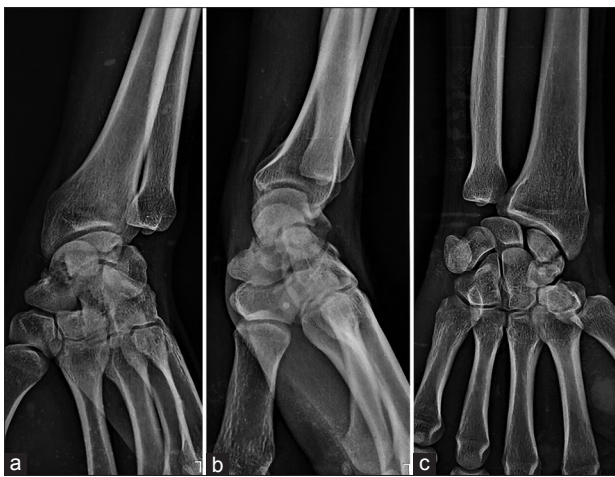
The radiograph showing fracture of scaphoid in oblique (a) and two orthogonal views (b and c). There is, however, area of cystic lucency surrounding fracture line and the rest of the bones appear normal
